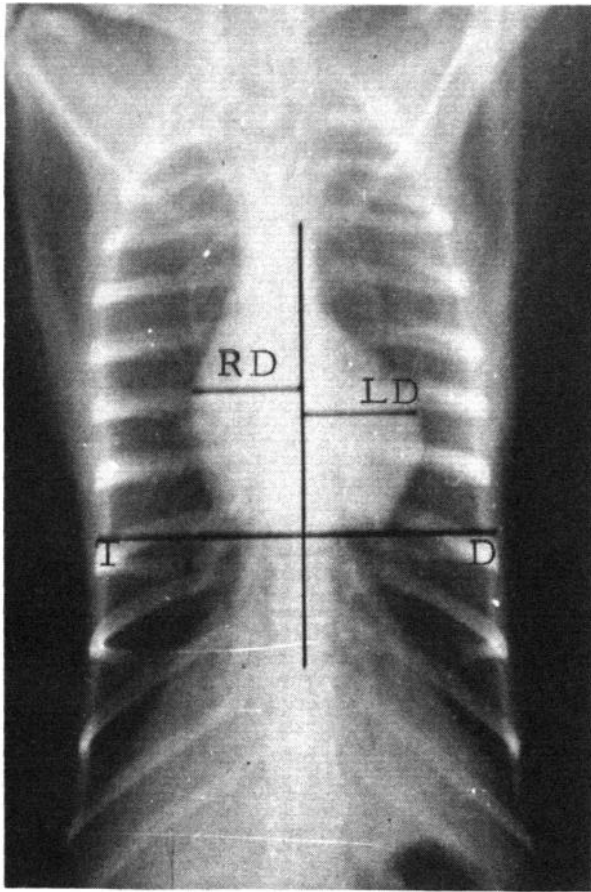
An X-ray showing the measurements used to derive the cardiothoracic index. RD is the maximum transverse diameter of the right half of the heart; LD is the maximum transverse diameter of the left half of the heart; and TD is the thoracic diameter.
